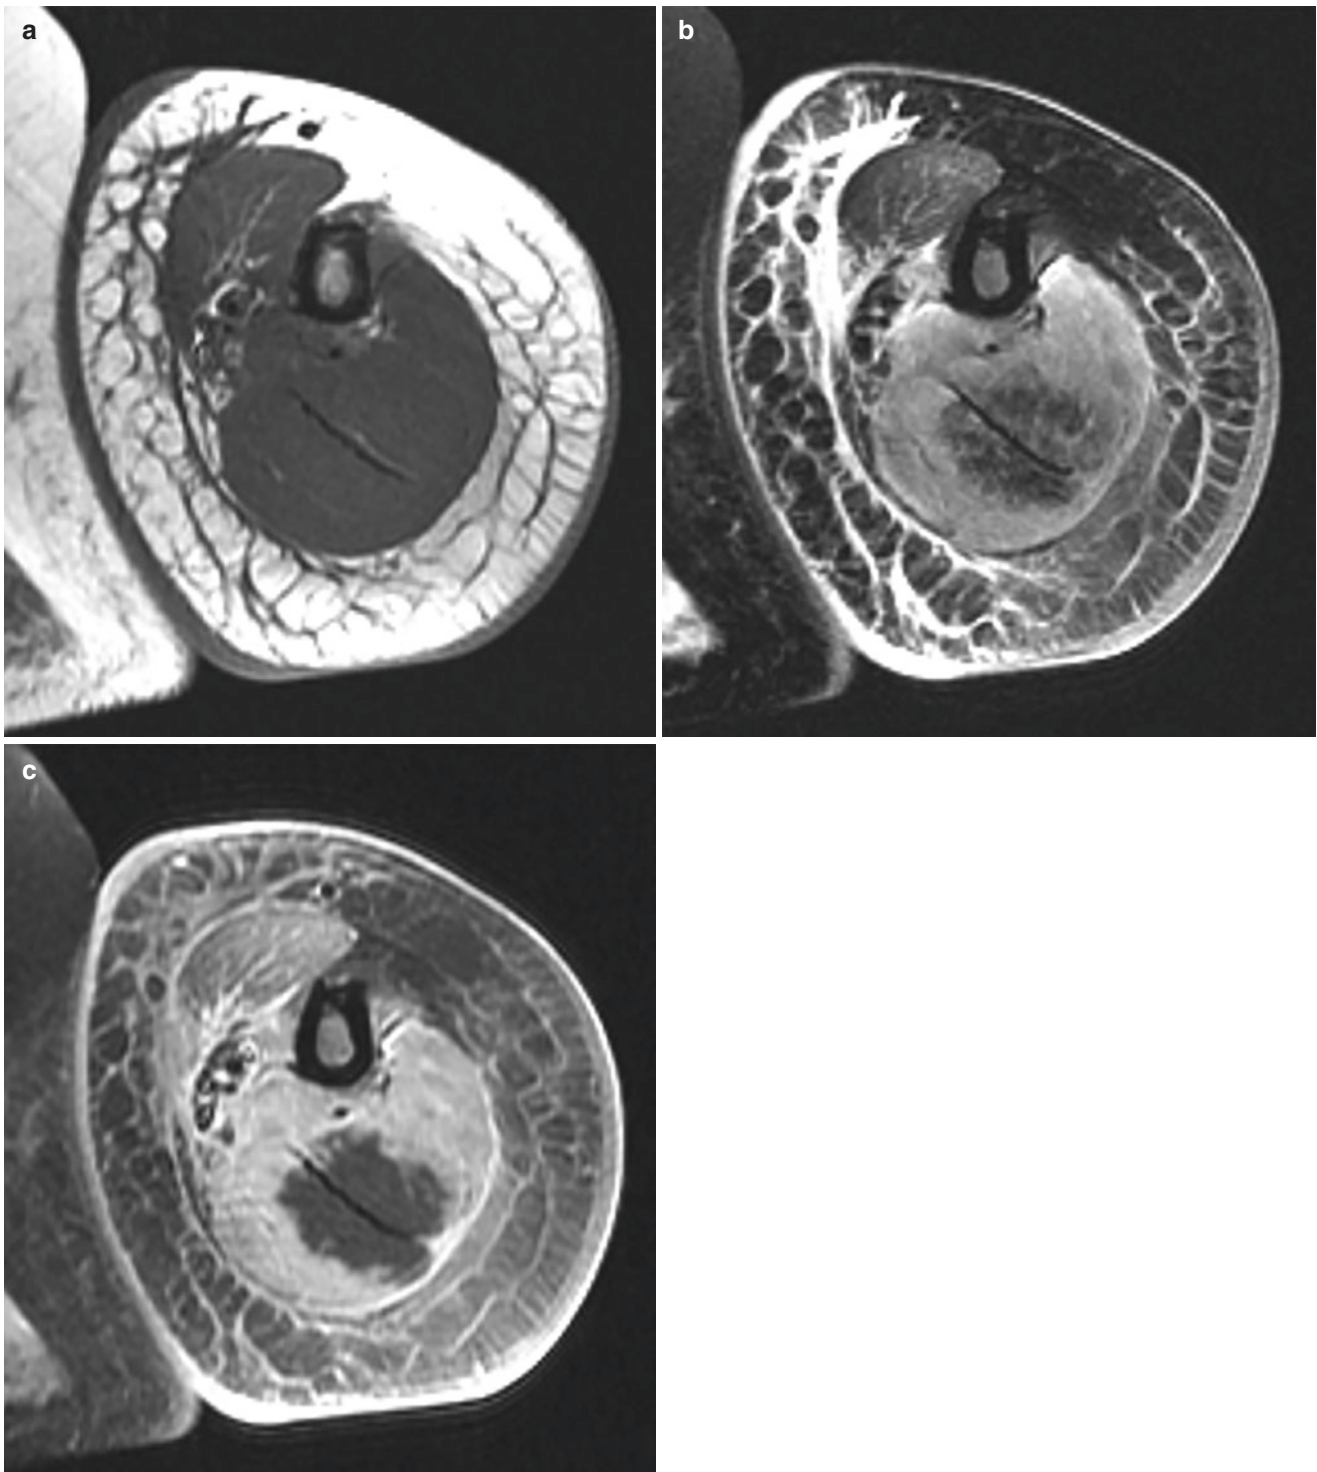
Myonecrosis in a 73-year-old woman complaining of arm pain following drug overdose and stroke. (a) T1-weighted axial image shows swelling of the triceps muscle. (b) T2-weighted, fat-suppressed axial image shows diffuse edema of triceps muscle and low-signal
